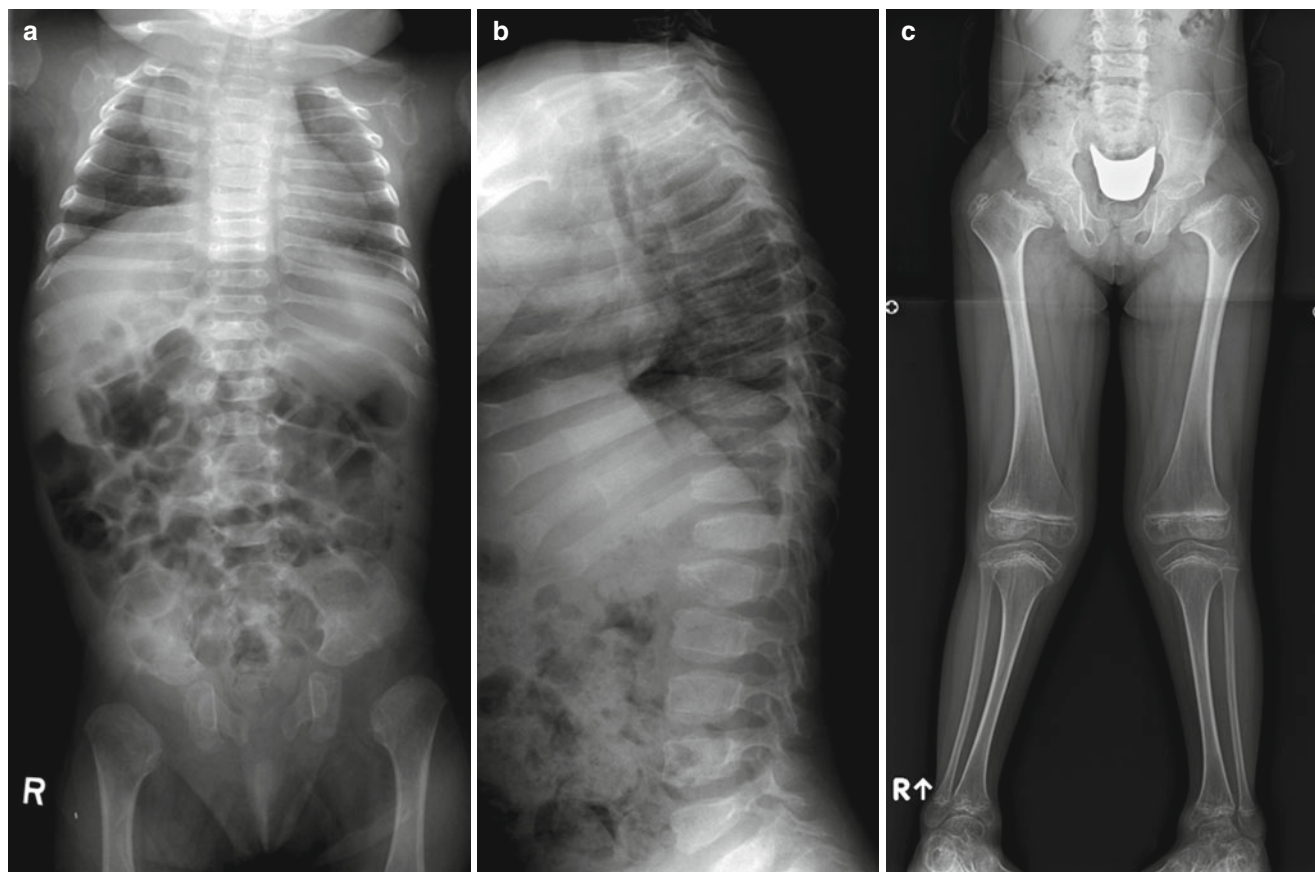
Kniest dysplasia*. (a–b) Spine radiographs of an 8-month-old girl show flat vertebrae with anterior wedging. The ilia are short and proximal epiphyses are not ossified. (c) Anteroposterior view of a
